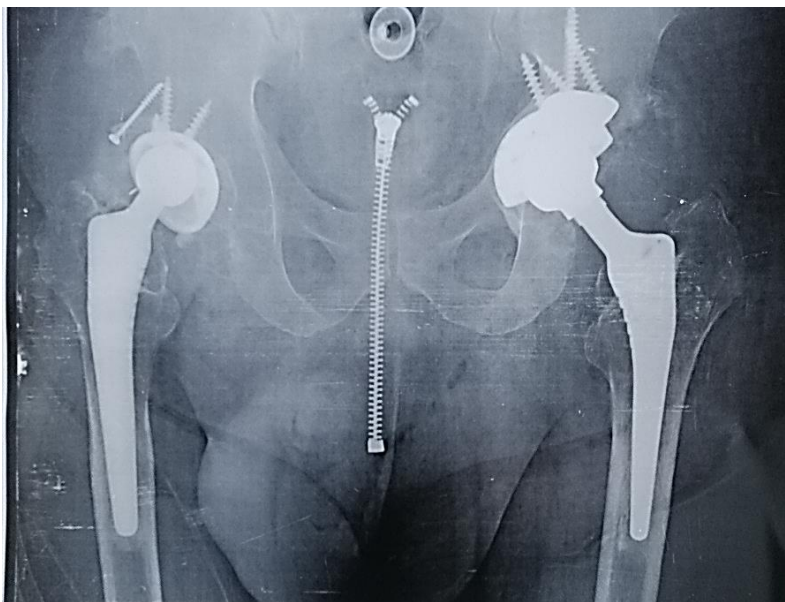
follow up x-ray after 3 months
